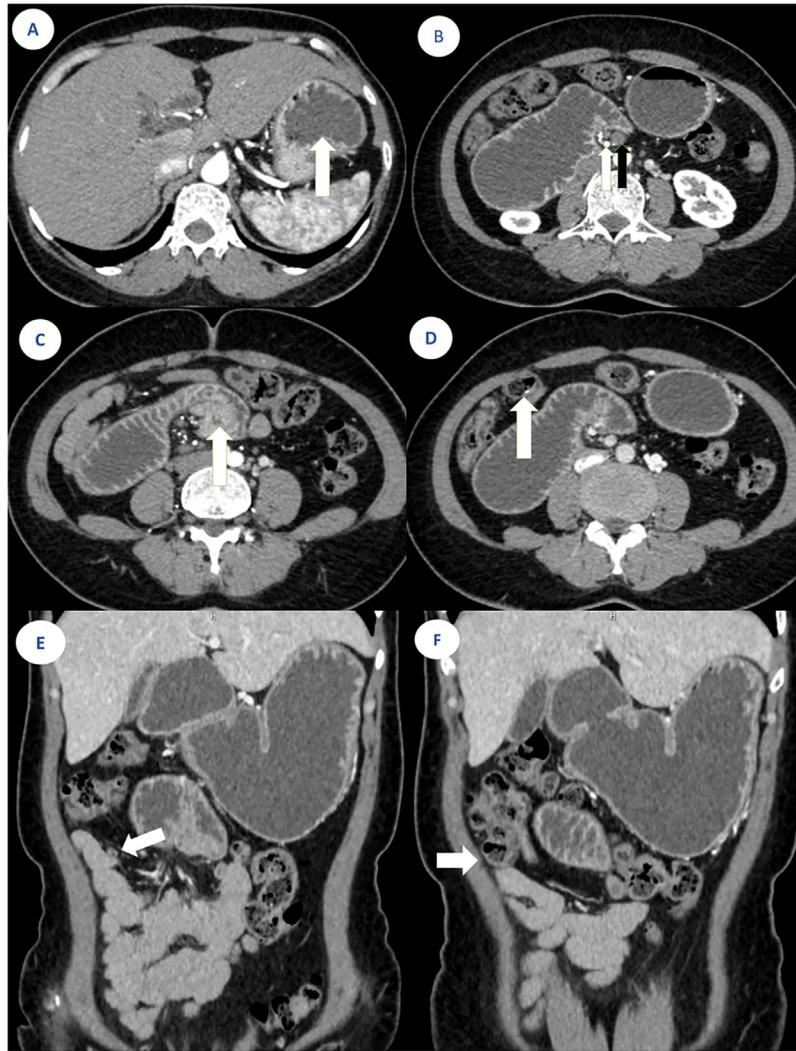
(A) The CT showed a normal stomach position (white arrow). The dilated D3 segment was anterior to the superior mesenteric artery. (B) The superior mesenteric vein (black arrow) was anterior and to the left of the superior mesenteric artery (white arrow). (C) The D3 segment showed a sudden narrowing (white arrow). (D) The cecal gas shadow (white arrow) was on the patient's right lumbar area rather than the right iliac fossa. The appendix (white arrow in E) and cecum (white arrow in F) were on the right lumbar in coronal images.
